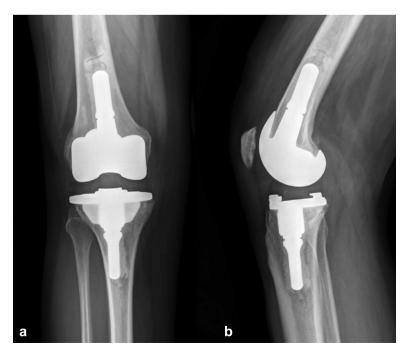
Postoperative (a) AP and (b) lateral radiographs after revision total knee arthroplasty.
